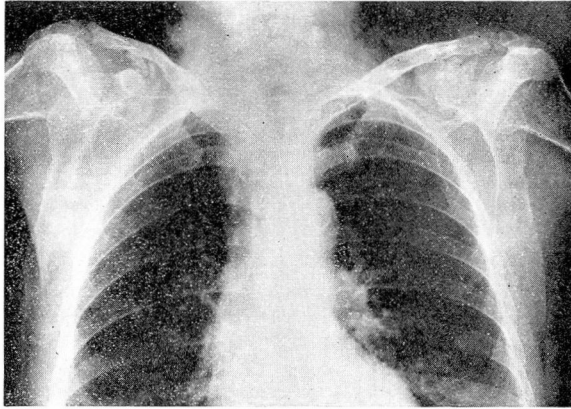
Case 2. Roentgenogram showing metastatic calcification in region of clavicles.
